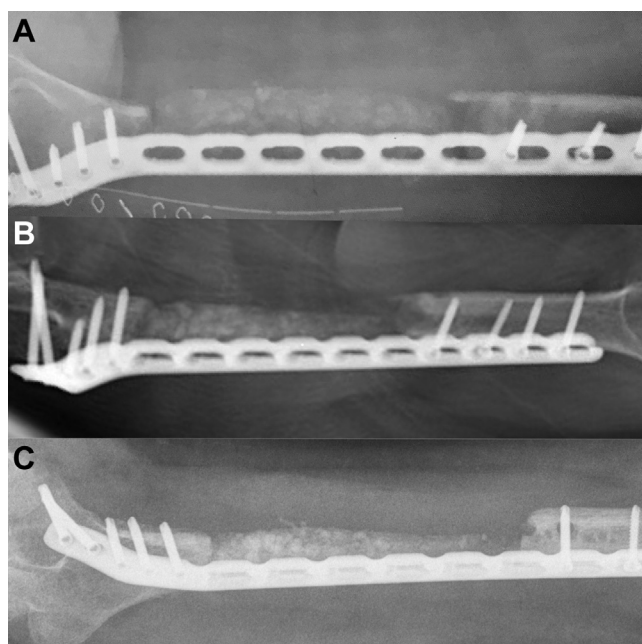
Follow-up radiographs after stage 2: (A) post-operative; (B) 6 weeks; (C) 12 weeks.
